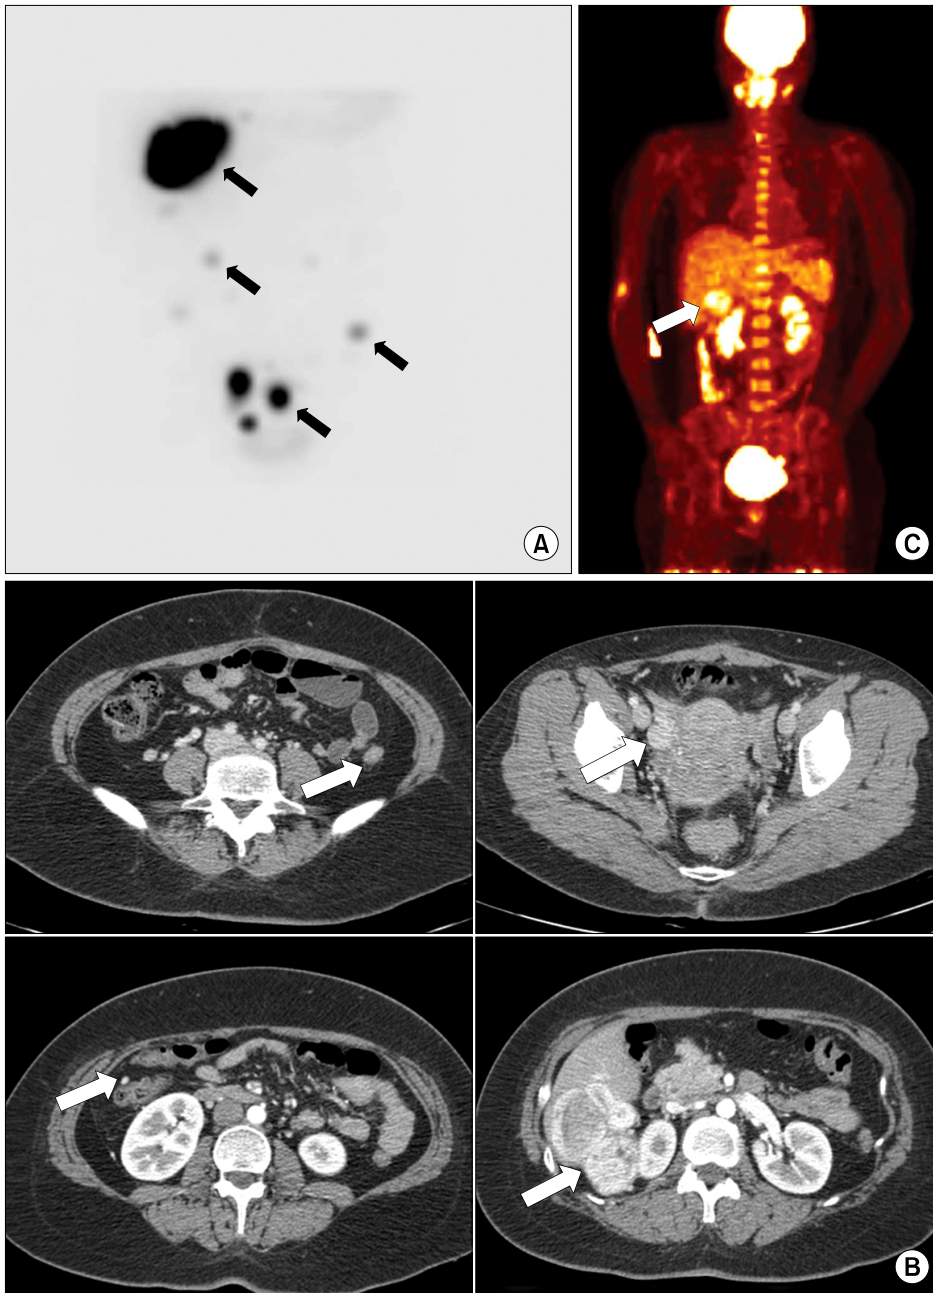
Imaging studies of the metastatic struma ovarii. (A) An iodine-131 scan after radioactive iodine therapy. This test revealed several nodules in the right upper quadrant of the abdomen (liver, arrow), peritoneum (arrow), and pelvic cavity (arrow). (B) Computed tomography scans showing an enhanced conglomerate nodular mass (arrow) in segment 6 of the liver with several daughter nodules and multiple seeding nodules (arrow). (C) The fluorodeoxyglucose-positron emission tomography (¹⁸F-DG-PET) scans showing increased uptake in the exophytic liver mass (arrow) and lymph nodes in neck level II.
